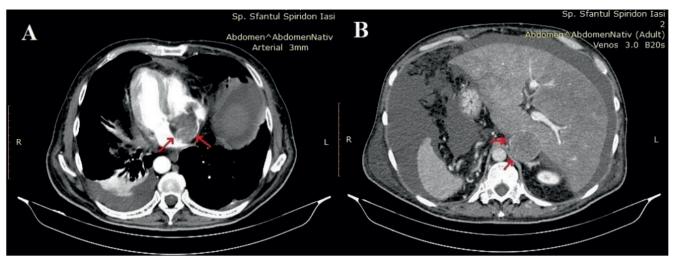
A. Thoracic CT arterial phase - axial view. Soft tissue mass occupying the right atrium almost completely, continued by thrombosis at the same level, with free right atrial appendage; pleural effusion. B. Abdominal CT venous phase - axial view. Filling defect of the IVC due to intraluminal non-homogeneous mass, with a diameter disproportionate larger than the aorta on the right (IVC largest diameter 53 mm); ascites.
